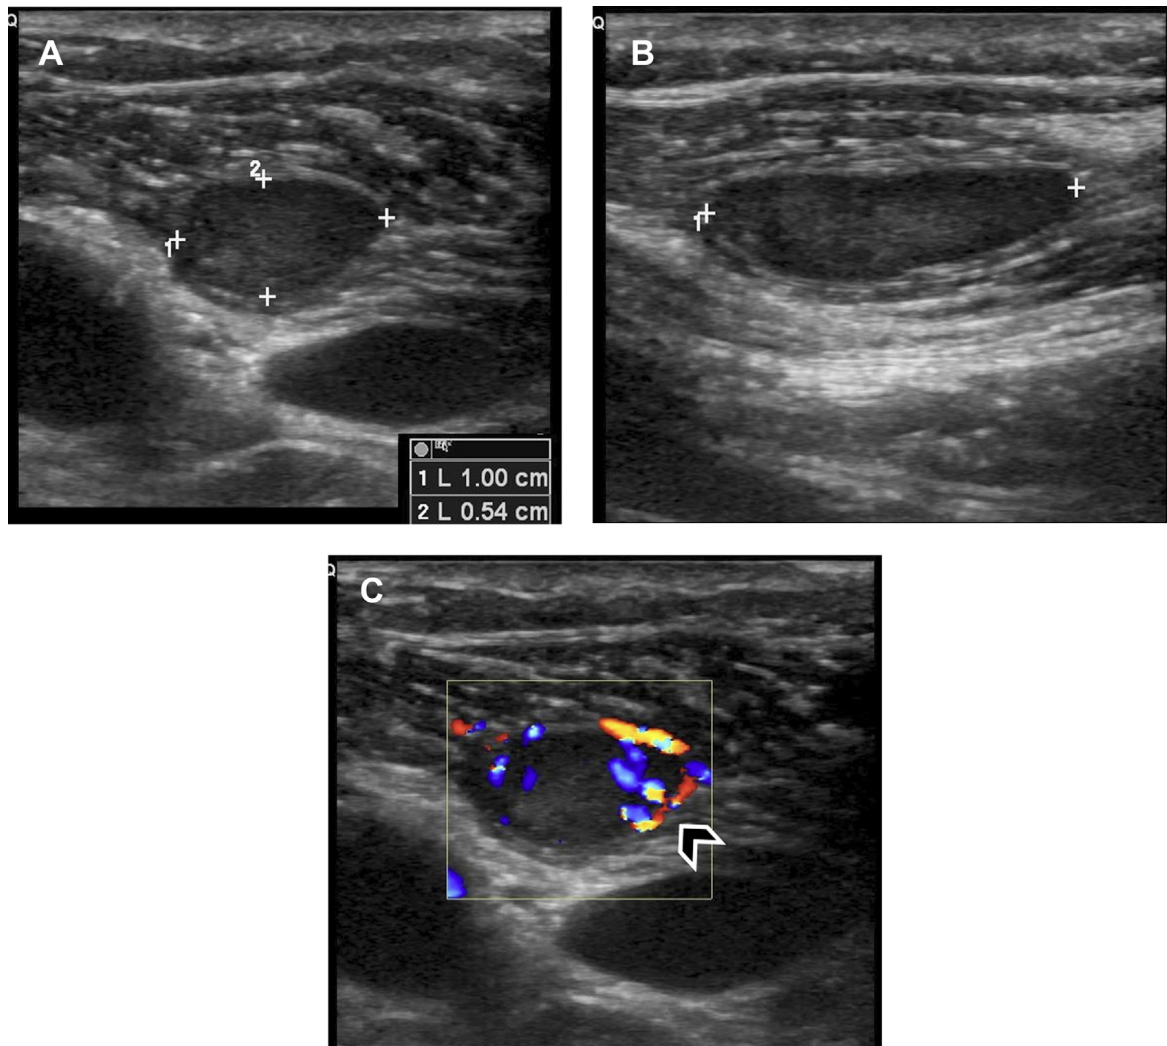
Ectopic parathyroid adenoma. (A) Axial and (B) sagittal B-mode and (C) axial color Doppler images in a 45-year-old man with prior history of papillary thyroid cancer status post thyroidectomy and parathyroidectomy 19 years ago, with parathyroid reimplantation in the left forearm presents with persistent elevated calcium and elevated parathyroid hormone level of 120 pg/mL (reference range 14–64). Neck ultrasound images demonstrate a hypoechoic nodule (*cursors* in A and B) along the cervical lymph node chain at level 3 overlying the great vessels with internal vascularity (*arrowhead* in C) and a prominent feeding vessel. The radiologic differential considerations were recurrent metastatic lymph node versus ectopic parathyroid adenoma. Thyroglobulin levels in the serum and in the nodule aspirate were undetectable (<0.1 ng/mL). Cytology and surgical pathology were consistent with parathyroid adenoma.
